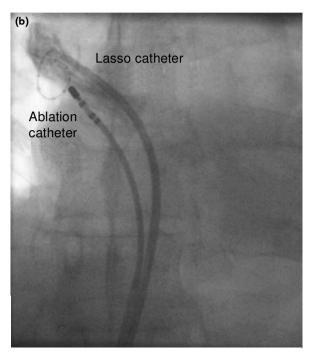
Comparison of an empirical anatomical approach with electrical isolation of the right pulmonary vein for the ablation of atrial fibrillation: (a) Empirical anatomical isolation of the right superior pulmonary vein (RSPV). An image of the left atrium and four pulmonary veins recorded with a Carto cardiac mapping system displayed in two views: anterior (ANT) (upper) and looking at the left atrium directly from the RSPV (lower) (four colour tubes = pulmonary veins; grey = body of the left atrium; red marks = individual lesions of radiofrequency ablation). A ring of lesions has been applied enclosing the RSPV, but well outside its ostium. There is no attempt to show that the vein is electrically isolated from the rest of the left atrium (LIPV = left inferior pulmonary vein; LSPV = left superior pulmonary vein; POST = posterior; R = right; RIPV = right inferior pulmonary vein). (b) Electrical isolation of the right superior pulmonary vein (RSPV). An X-ray image of the heart from the anteroposterior projection. Contrast has been injected into the RSPV. A 'lasso' catheter with 10 electrodes is used to confirm whether the vein is electrically isolated from the rest of the left atrium. A steerable mapping/ablation catheter is used to deliver radiofrequency energy until electrical isolation of the pulmonary vein is achieved.
